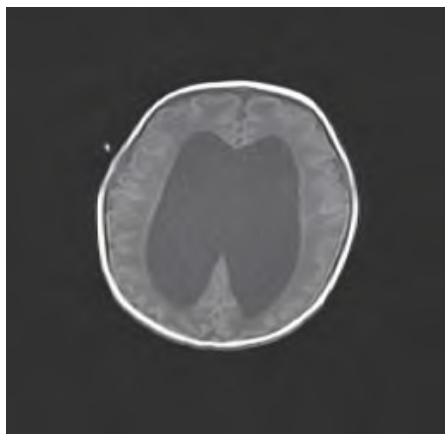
A brain MRI showing bilaterally enlarged ventricles with an absent septum pellucidum.
